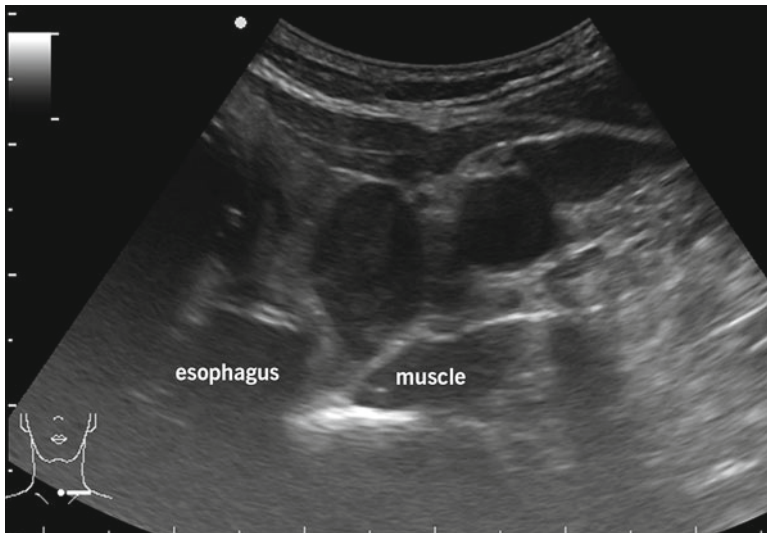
The “triple circle” sign refers to the three dark circles imaged on transverse view during parathyroid ultrasound. These are purposefully unlabeled to be seen in contrast to the esophagus and underlying muscle. The
